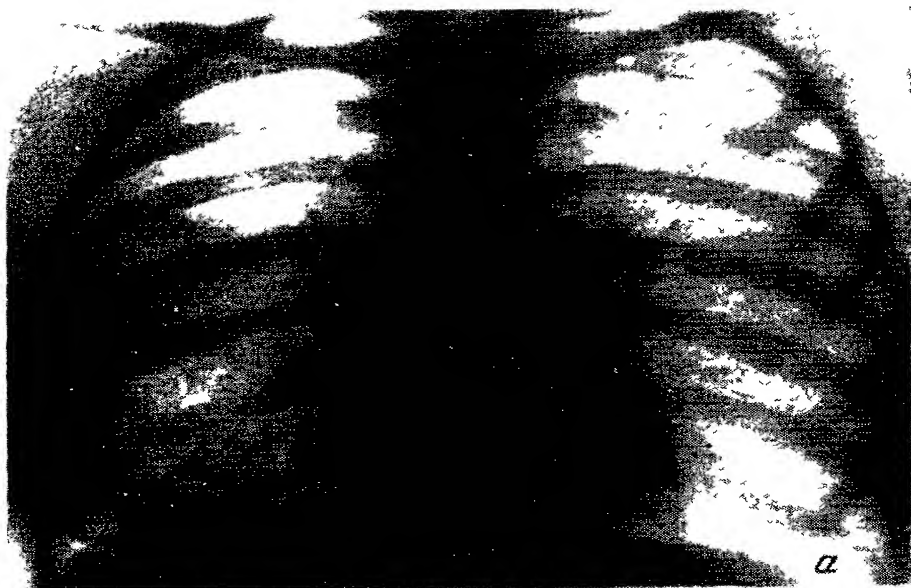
Lung X-rays of patient P
